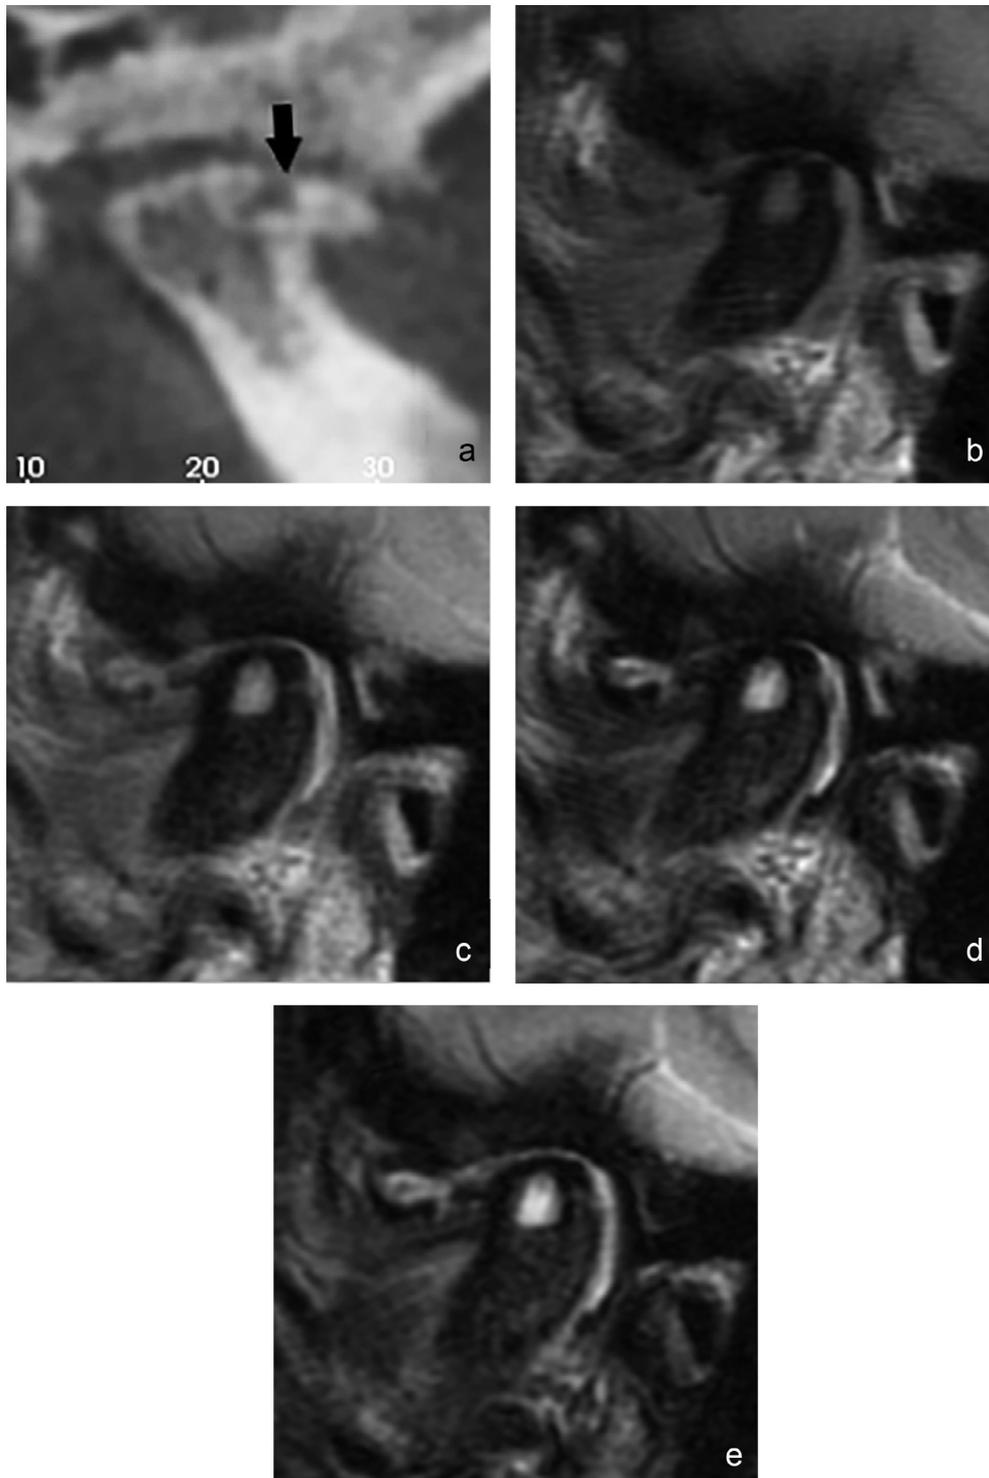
This series demonstrates the appearance of a subchondral bone cyst with multiple protocols. (a) CBCT shows a well-defined low density structure just deep to the articular surface connected to the surface with a small low density "tail". On a different patient, the MR images are of the same condyle and show the signal differences between protocols. (b) T1, (c) PD, (d) T2, (e) STIR (Courtesy, M. Noujeim DDS, MS).
